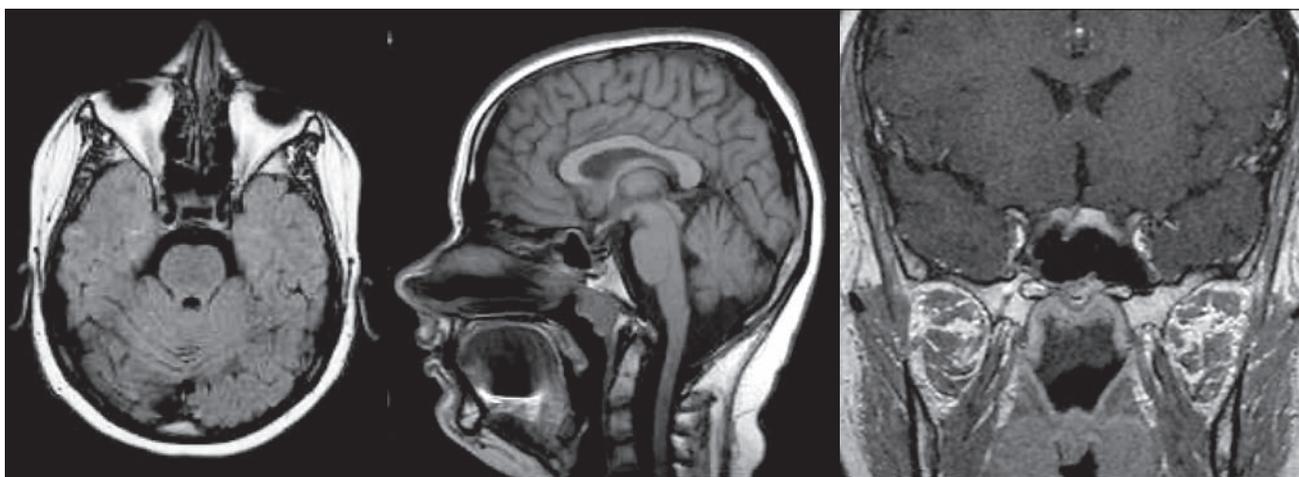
Cerebral MRI: no signs of pituitary tumor or recurrent pituitary abscess one month after surgery
